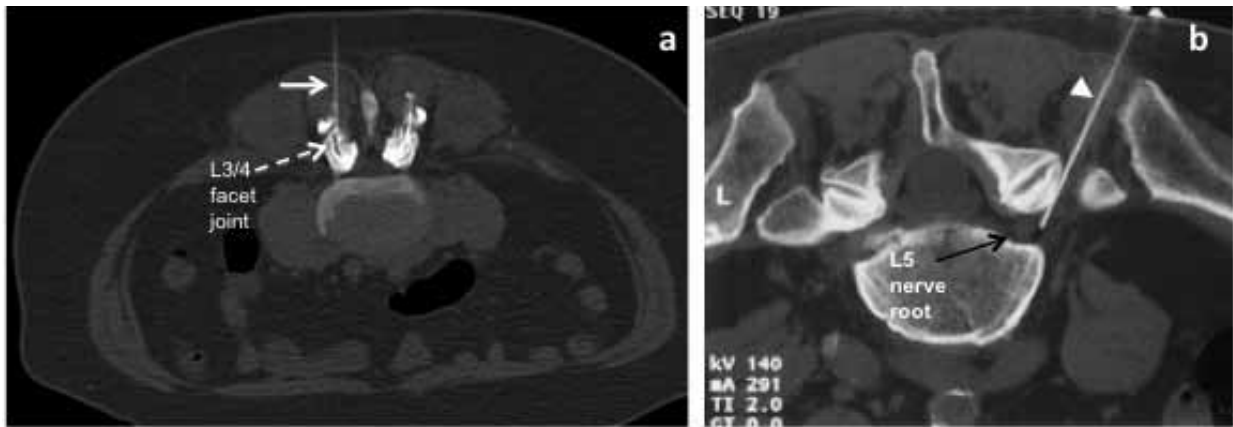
Therapeutic interventions. (a) CT axial image of prone patient shows peri-articular injection using 22-gauge spinal needle (arrow) into degenerative right L3/4 facet joint (dashed arrow). (b) CT-guided needle placement (arrowhead) lies adjacent to the right L5 nerve root sleeve (black arrow).
